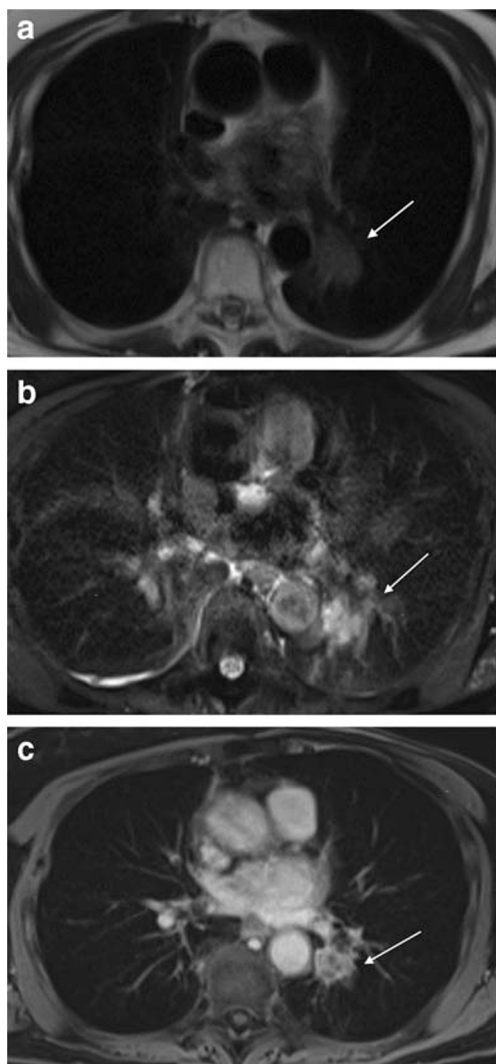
Biopsy proven non-small cell lung cancer. a Axial T2-weighted without and b with fat saturation show a spiculated soft tissue mass in the superior segment of the left lower lobe. Notice how the spiculations are well identified on MRI similar to CT. There is avid but heterogeneous enhancement on axial T1-weighted gradient echo image (c)
